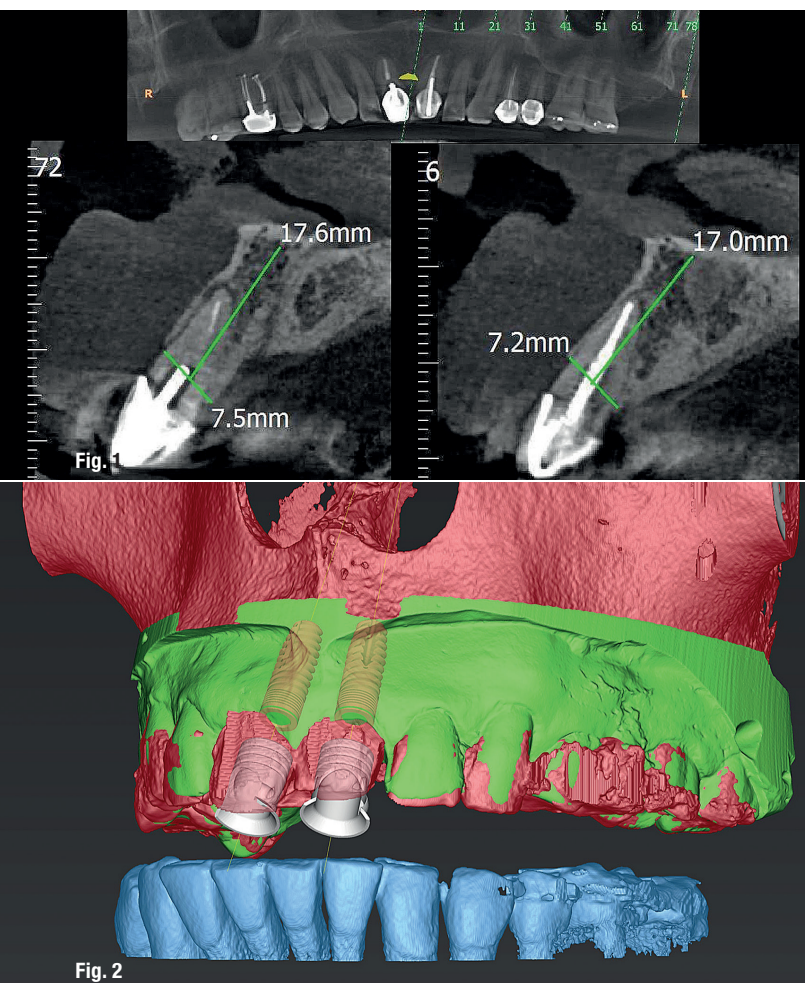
Pre-op CBCT showing periapical lesion at teeth #11 and 21.
